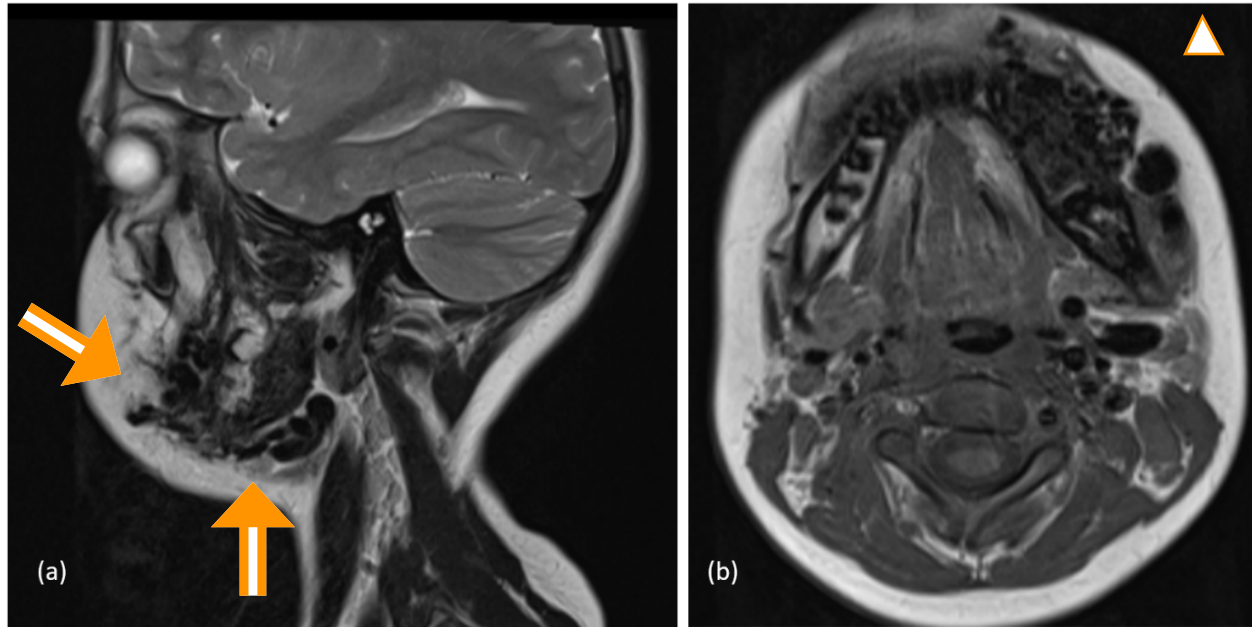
CASE 2: (a) T2 sagittal (b) T1 axial sections of the MRI neck show dilated tortuous flow voids (arrows), with a nidus seen in the left mandibular region (arrow head), involving the buccinator and body of mandible.
